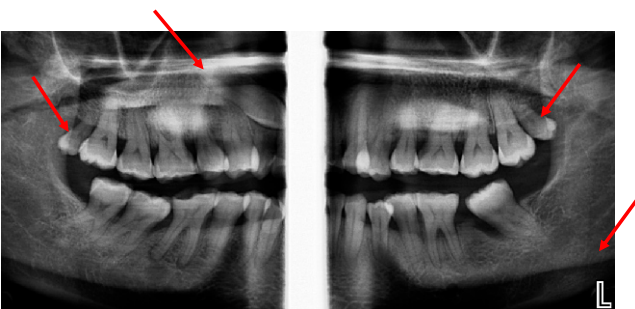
Sectional panoramic radiograph) of 44-year-old male patient with bilateral maxillary distomolars.
